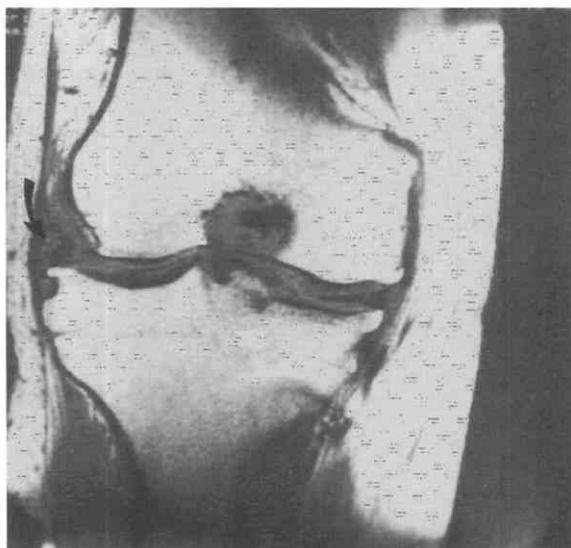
Osteoarthritis. Coronal T1-weighted image shows marked lateral compartment narrowing, osteophyte formation, and lateral subluxation of the tibia. The lateral meniscus is degenerated, and what remains rests beyond the margin of the joint (arrow).
